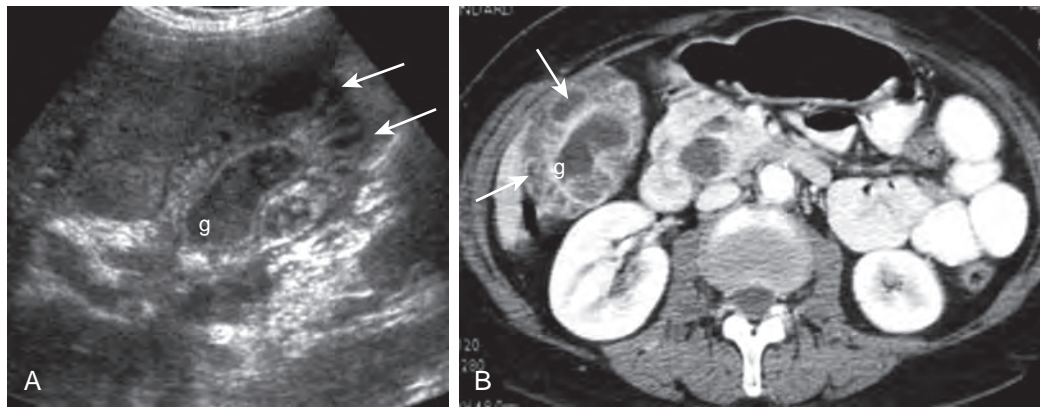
Xanthogranulomatous cholecystitis. A. Ultrasound demonstrates intraluminal echogenic material due to sludge. Gallbladder (g) wall is markedly thickened and contains hypoechoic nodules (arrows). B. Contrast-enhanced CT demonstrates marked gallbladder (g) wall thickening and hypoattenuating mural nodes (arrows).
